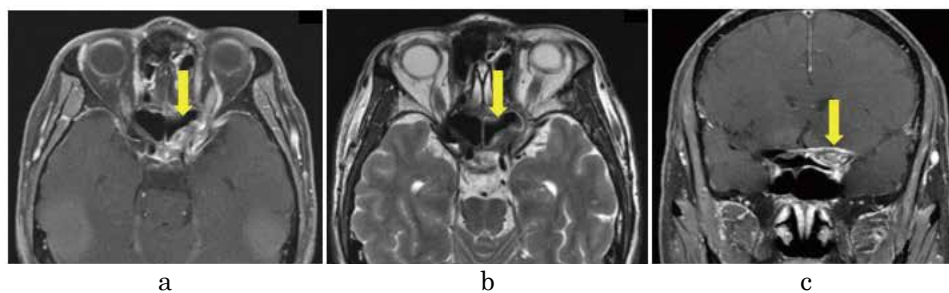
Contrast-enhanced axial MRI scan showing a mass with contrast enhancement (a) and a low-intensity signal on a T2-weighted image (b) along the left optic canal extending to the left posterior ethmoid sinus and the cavernous sinus (arrow). Contrast-enhanced MRI scan (c) showing enhancement of the dura mater at the point of contact with the mass (arrow).
